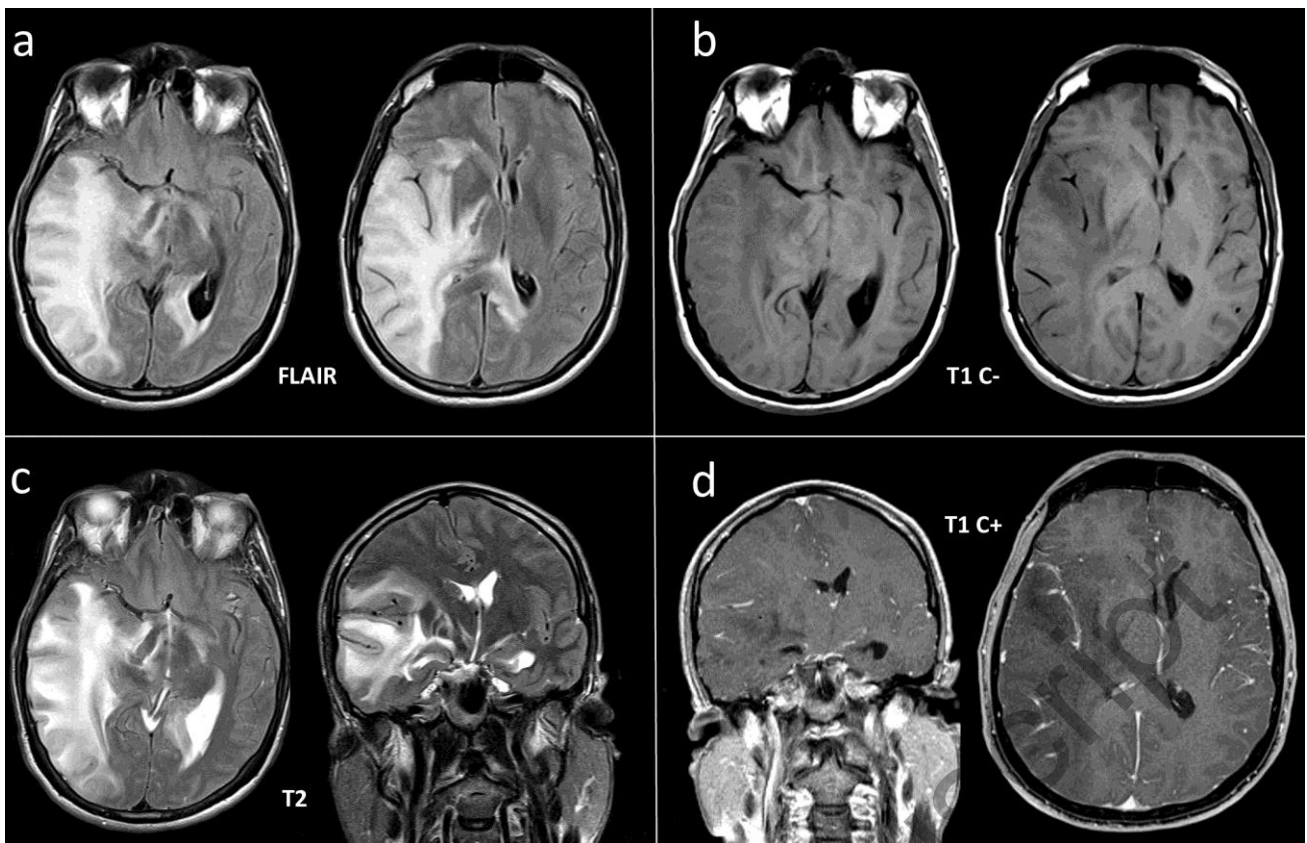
Head MRI, axial and coronal view: extensive vasogenic edema of the white matter in the right hemisphere, involving the isthmus and splenium of the corpus callosum bilaterally and, through the cerebral peduncles in correspondence of the cortico-spinal bundles, in subtentorial region. Marked diffusion restriction of the parieto - insulo - temporal and occipital cortical area on the right was associated. Hyperintense T2-signal is also observed in the right optic tract and in the bulbar pyramids. The extensive edema determines a marked compressive effect on the right lateral ventricle with associated compensatory dilatation of the left lateral ventricle and posterior interstitial edema. After contrast medium, a nuanced and inhomogeneous impregnation is observed at the margins of the vasogenic edema.
